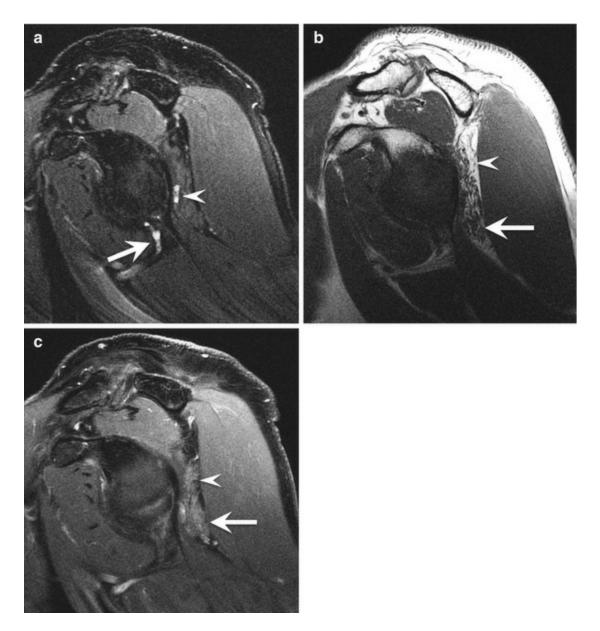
Suprascapular nerve and axillary nerve neuropathies due to labral cysts. (a) Sagittal fat-suppressed T2-weighted MRI shows two labral cysts, the lower (arrow) extending into the quadrilateral space, the posterior (arrowhead) extending medially towards the spinoglenoid notch. (b) Sagittal T1-weighted MRI shows infraspinatus
